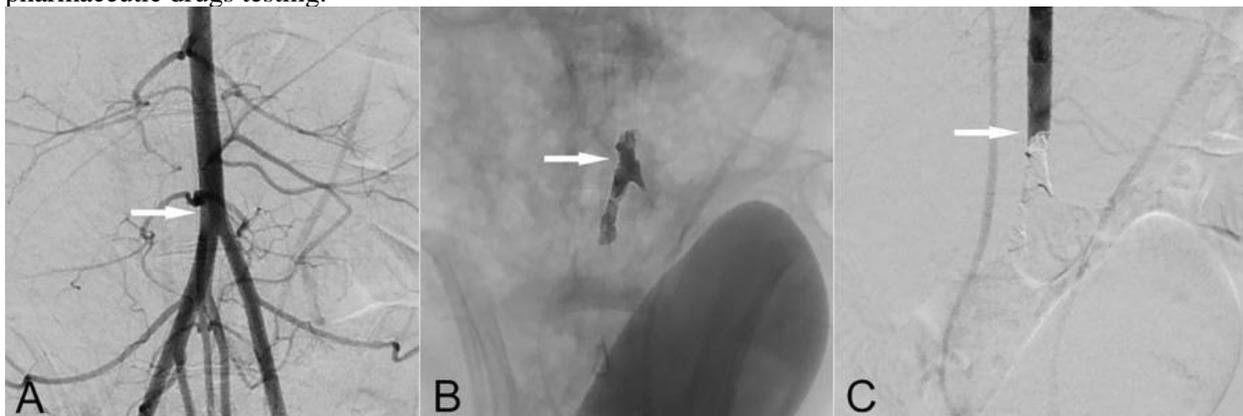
A. DSA before clot injection, showing distal aorta and its bifurcation (white arrow); B. Plain film after clot injection, indicating clot at the bifurcation of distal aorta (white arrow); C. DSA after clot injection, indicating complete occlusion of distal aorta (white arrow).
